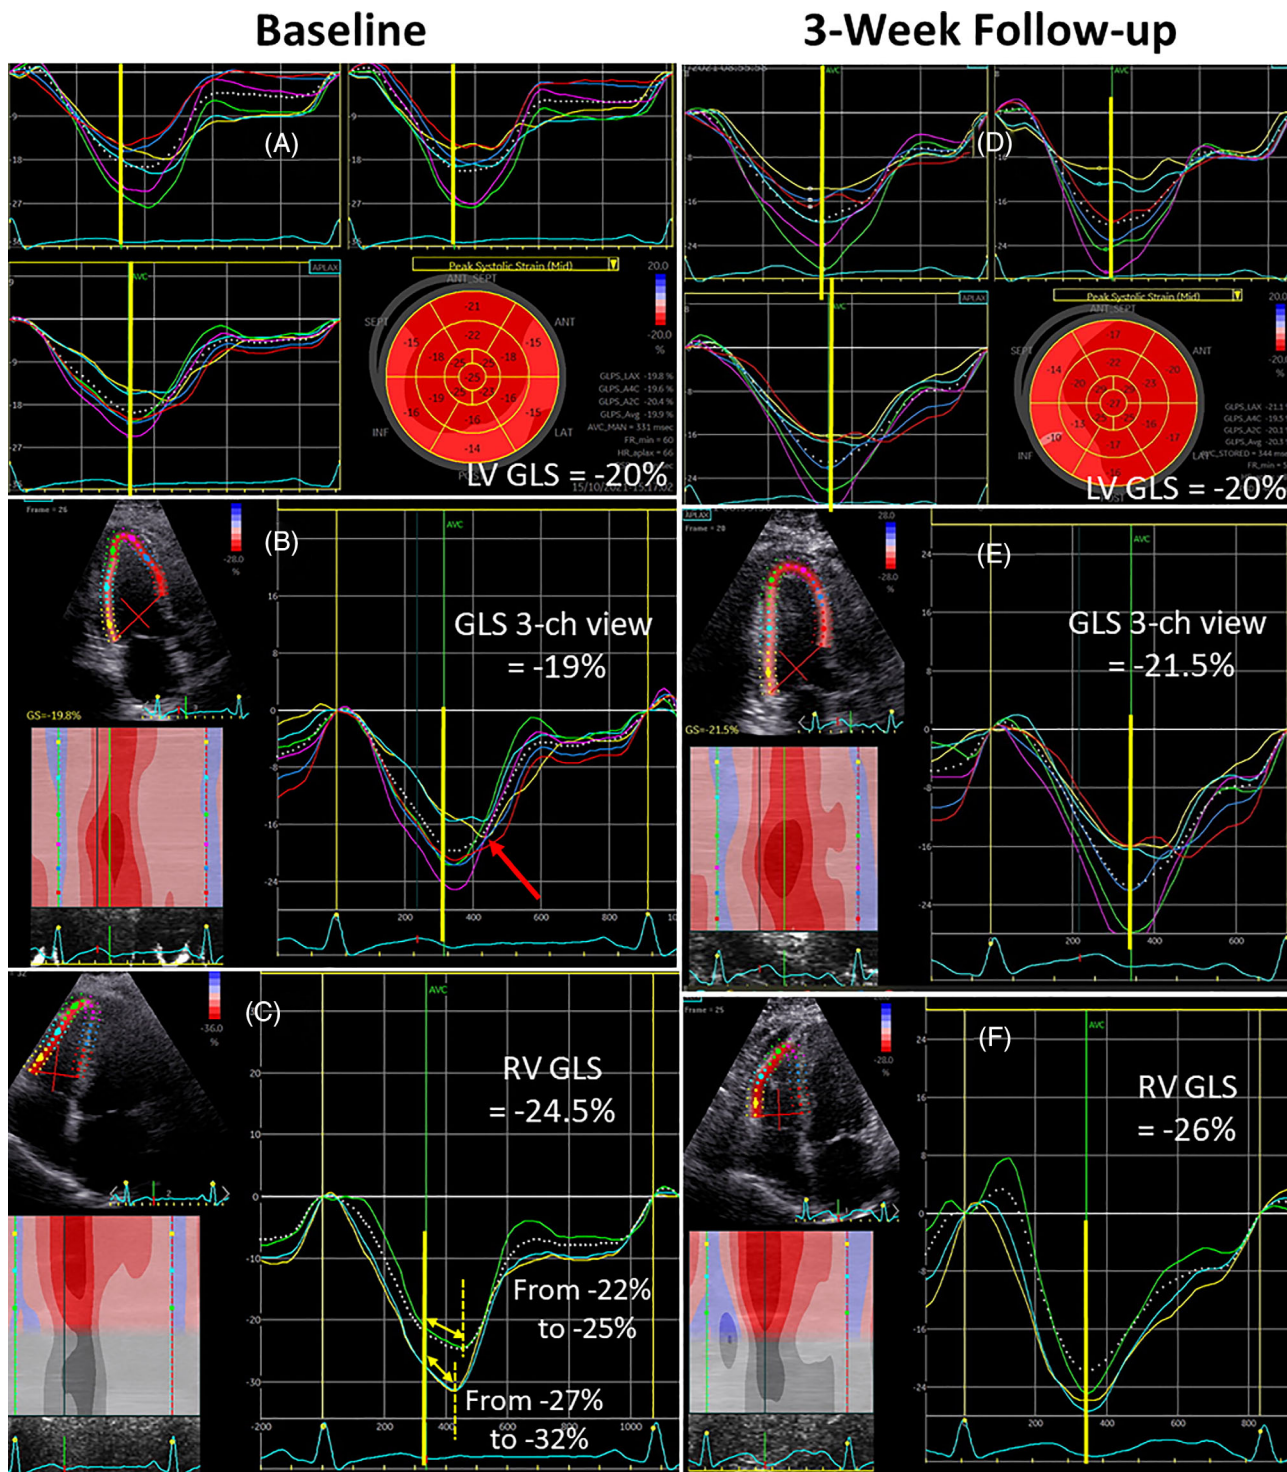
Two-dimensional speckle tracking echocardiography images, showing improvement (more negative values) of LV-GLS and regression of RV-GLS from baseline (A–C) to 3-week follow-up (D–F). GLS, global longitudinal strain; LV, left ventricular; RV, right ventricular
